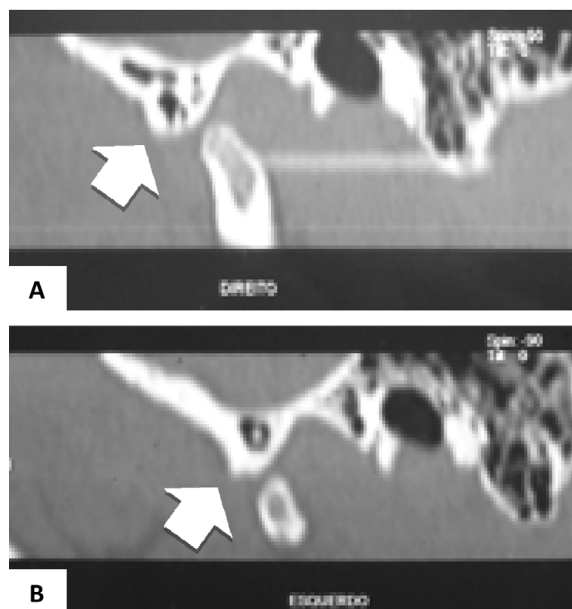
Case 1, computed tomography showing the pneumatization of the articular eminence (arrows); (A) right side and (B) left side.
